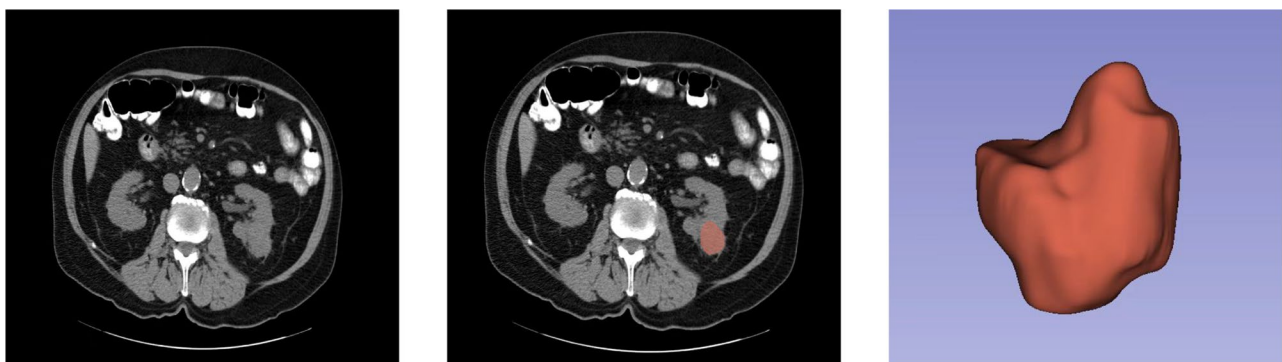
The ROIs were manually drawn layer by layer in ccRCC plain CT images using 3D Slicer 4.11 software
